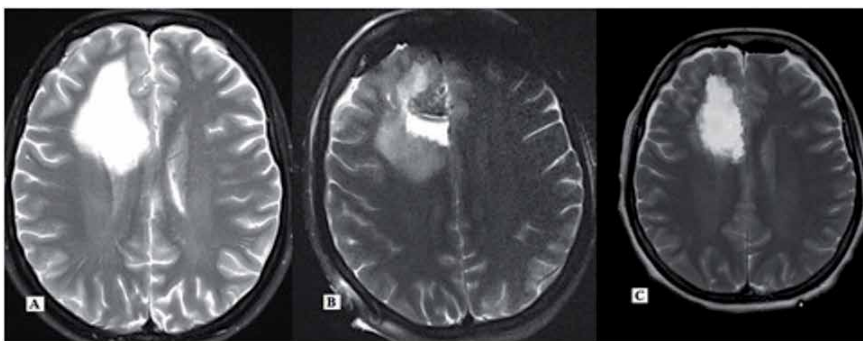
A. Preoperative MRI of a patient showing T2 hyperintense LGG involving right medial frontal lobe B. ioMRI showing residue around the surgical cavity which was excised in the same sitting. C. Post-op MRI showing.
